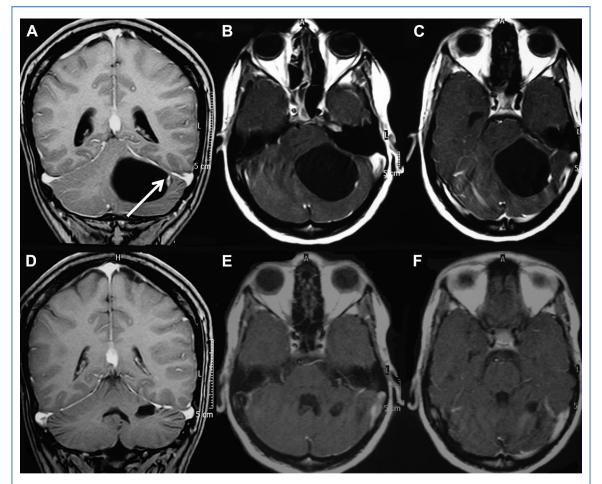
T1-weighted with gadolinium magnetic resonance image of patient 1. *Upper row*: preoperative images showing a large cystic lesion with a small, enhanced nodule just below the tentorium on coronal (A) and axial (B and C) cuts. The fourth ventricle is totally collapsed. The *arrow* shows the approach trajectory *Lower row*: postoperative images showing a small residual cerebellar cavity on coronal (D) and axial (E and F) cuts. The fourth ventricle returned to its normal shape and position.
